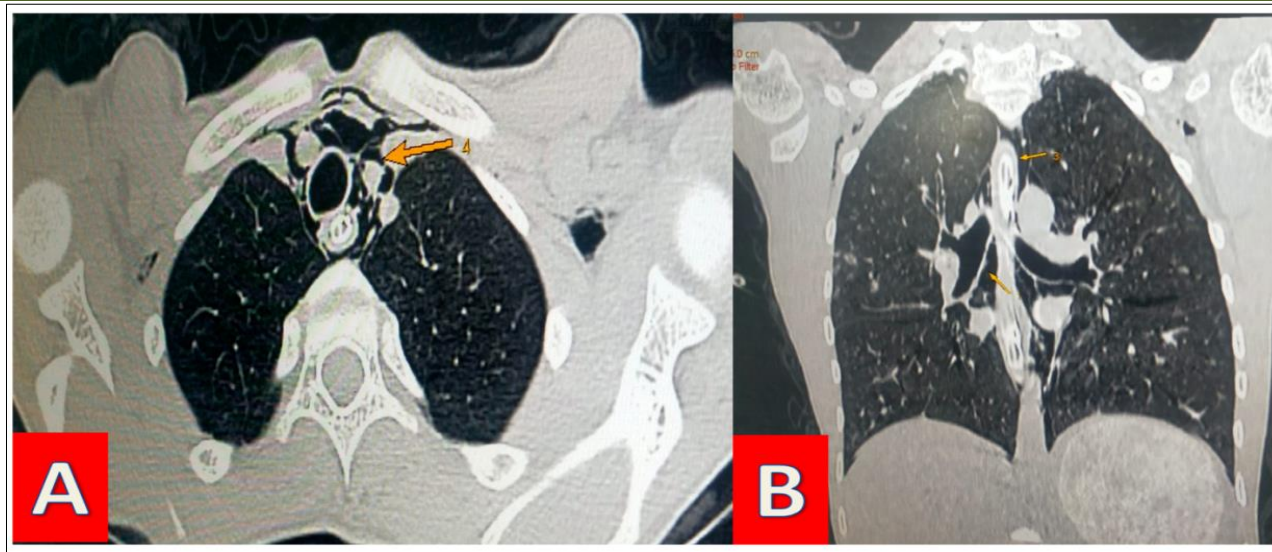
CT scan confirmed the pneumomediastium with the presence of radiological signs in favour of Boerhaave syndrome.
